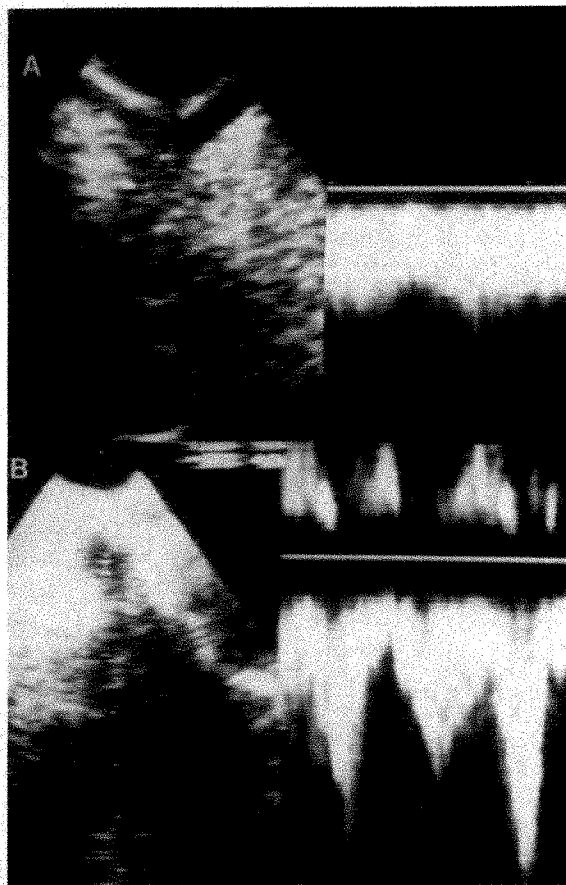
This 35-year-old woman with highly malignant non-Hodgkin's lymphoma localized in the upper and middle mediastinum was studied prospectively. Transthoracic echocardiography showed a large mass with parenchymal-like echogenicity, compressing the cephalic portion of the superior vena cava (A). Color and pulsed Doppler confirmed the presence of a disturbed flow. At transesophageal echocardiography the caudal portion of the superior vena cava appeared of normal shape and diameter. Doppler sampling showed a normal flow (B).
